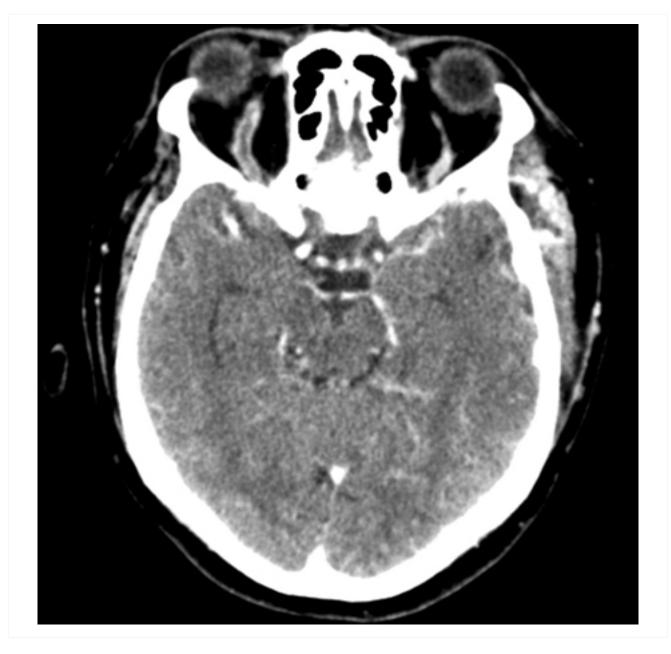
Postcontrast venous phase CT scan of the head (axial view) showing an enlarged 'S'-shaped right superior ophthalmic vein with associated proptosis
